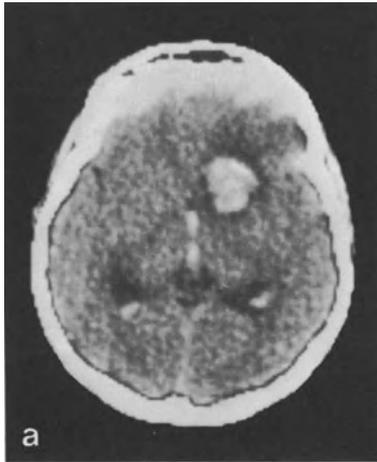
a CT of an intracerebral haematoma originating from a carotid-bifurcation aneurysm. b The slight space-occupying character of the haematoma manifests in a discrete displacement of the basal parts of the anterior cerebral artery. The bean-sized aneurysm of the carotid bifurcation can be recognized
